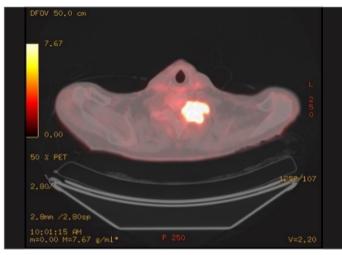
Hypermetabolic mass in the left paravertebral region (18F-FDG-PET/CT).
